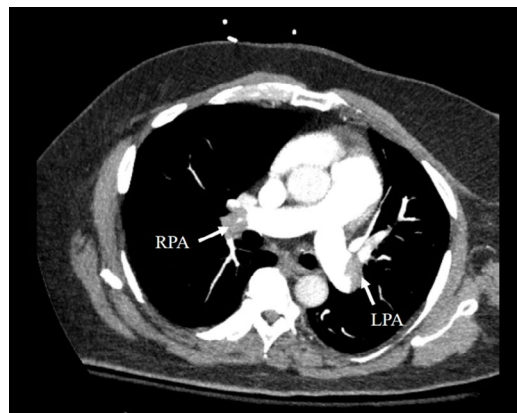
Computed tomography angiogram of chest (pulmonary embolism protocol) demonstrates large bilateral pulmonary artery embolisms (RPA right pulmonary artery; LPA left pulmonary artery).
